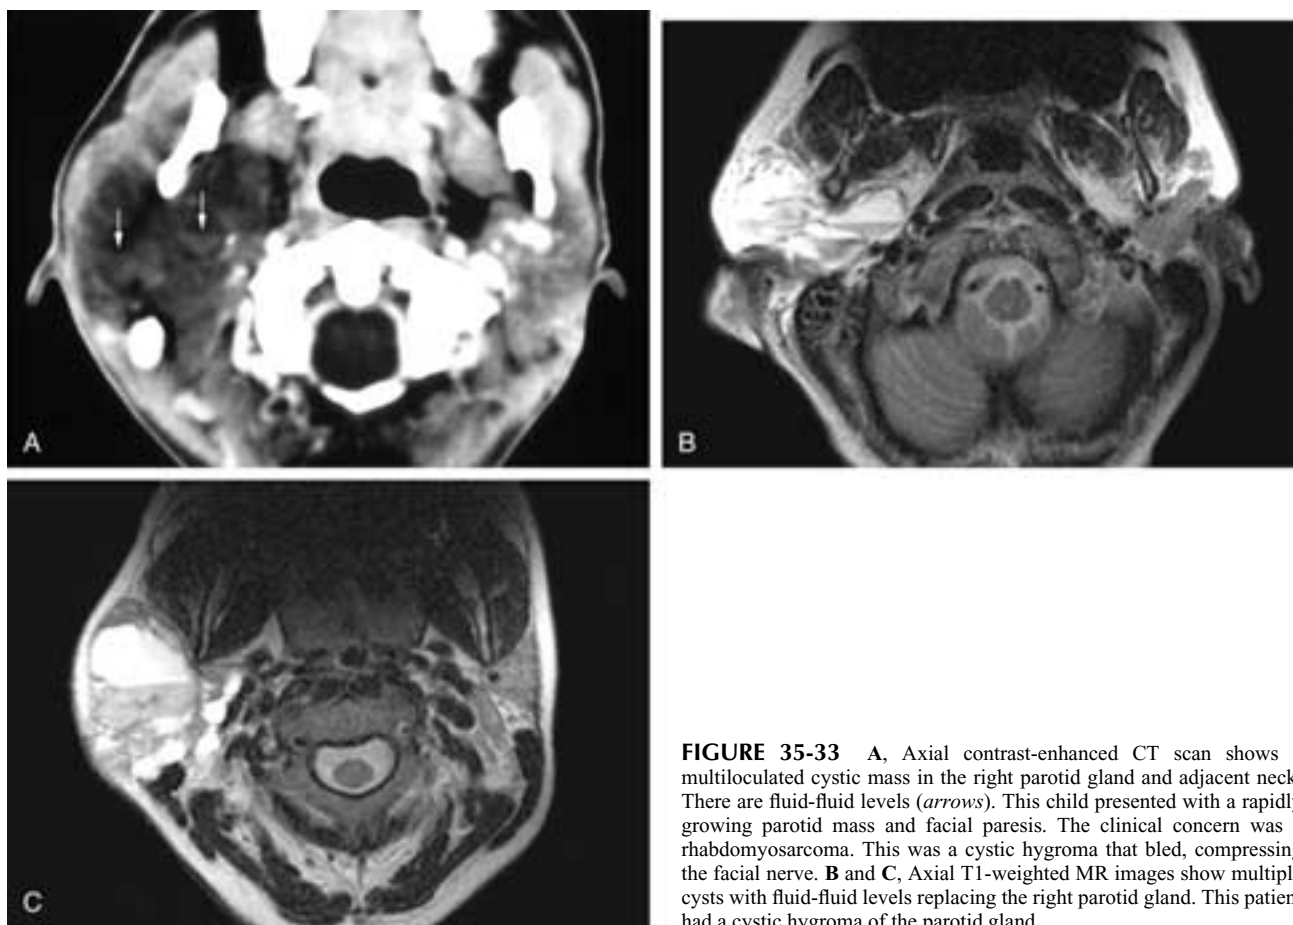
A, Axial contrast-enhanced CT scan shows a multiloculated cystic mass in the right parotid gland and adjacent neck. There are fluid-fluid levels (*arrows*). This child presented with a rapidly growing parotid mass and facial paresis. The clinical concern was a rhabdomyosarcoma. This was a cystic hygroma that bled, compressing the facial nerve. B and C, Axial T1-weighted MR images show multiple cysts with fluid-fluid levels replacing the right parotid gland. This patient had a cystic hygroma of the parotid gland.
